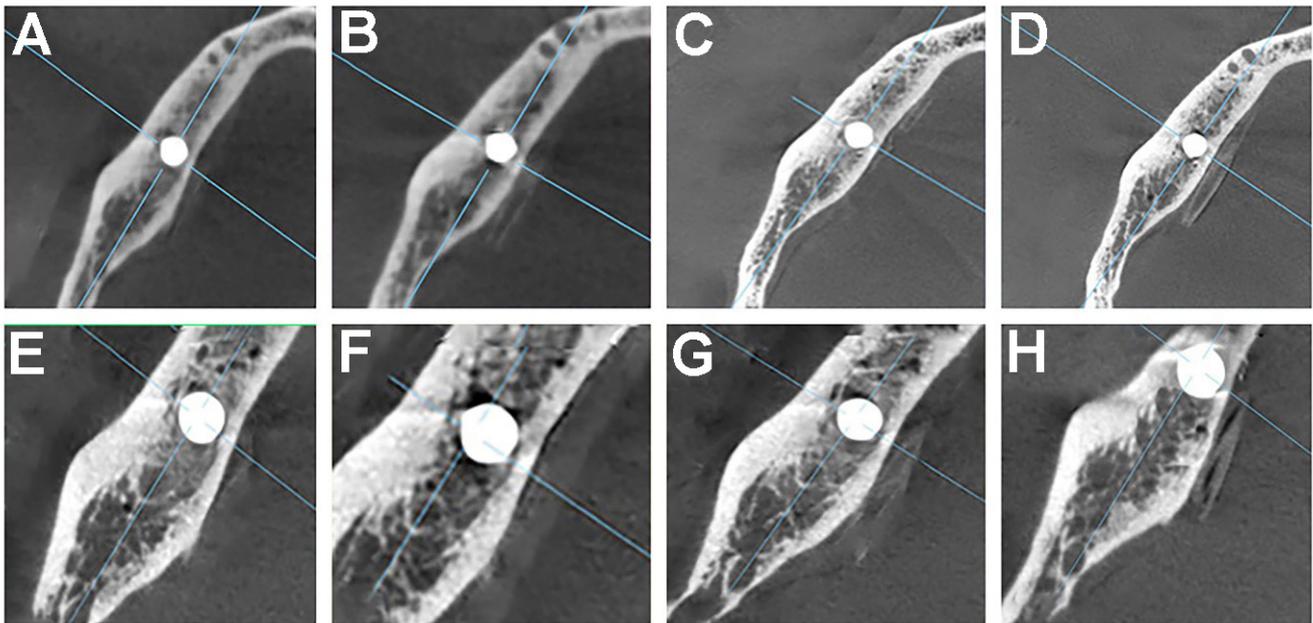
CBCT sections with different parameters in the axial plane
